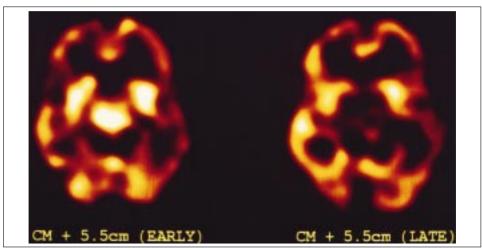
(c) Tc-99m HMPAO brain SPECT scan sections oriented parallel to and 5.5 cm above the canthomeatal line. The changes in blood flow to the thalamus from the one week post-stroke scan (left) are contrasted with the marked reduction of blood flow typically associated with infarction on the 2 month blood flow scan section (right).
